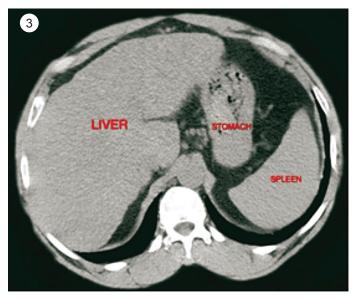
CECT abdomen (a) axial plane, arterial phase, and (b) coronal reformatted image delineate third part of duodenum compressed between the aorta and SMA (green arrow). Proximal duodenum and stomach are markedly dilated. Ryle's tube is noted in the stomach for nasogastric decompression. Fig. 2. Sagittal reformatted CECT of abdomen, arterial phase, shows aorto-mesenteric (a) distance of 5 mm, and (b) angle of 15 degrees. Arrows depict compressed duodenum. Fig. 3. CT plain abdomen at six months follow up depicting normal stomach.
